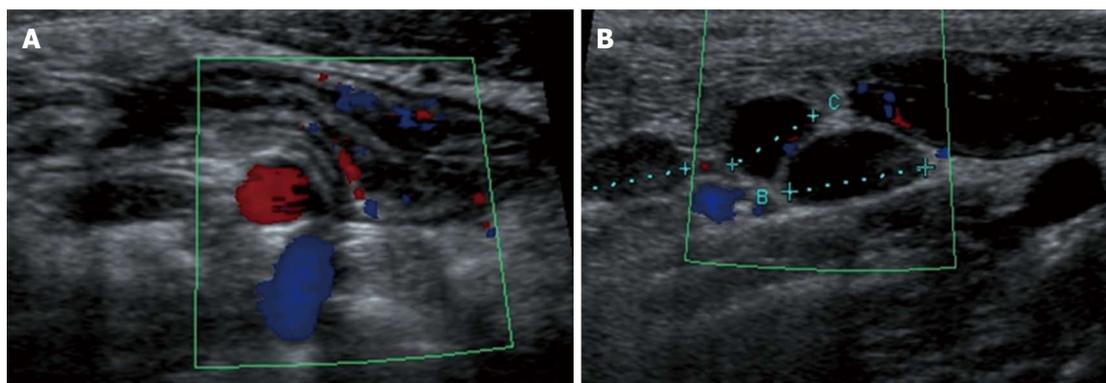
Longitudinal view of the terminal ileum in a 13-year-old boy with active Crohn's disease. The bowel wall is thickened and shows increase in Color Doppler signals denoting inflammatory hyperemia (A). Note in (B) the fibrofatty proliferation of the surrounding mesentery which appears hyperechoic and the enlarged mesenteric lymph-nodes.
